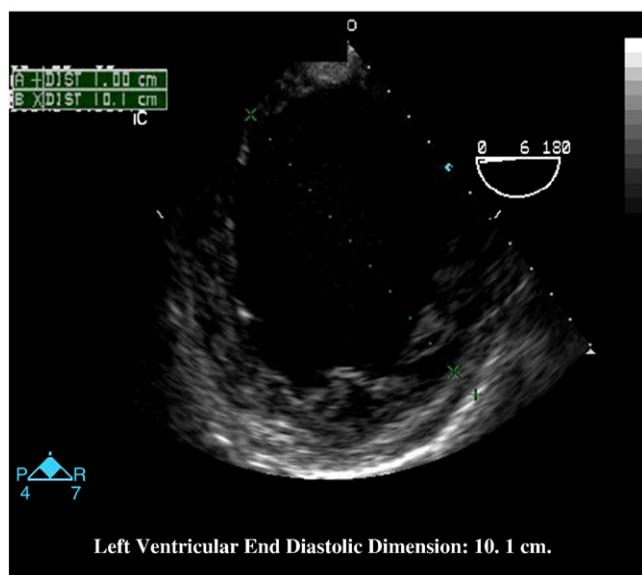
Transesophageal echocardiographic view of the patient's left ventricular dilatation.
